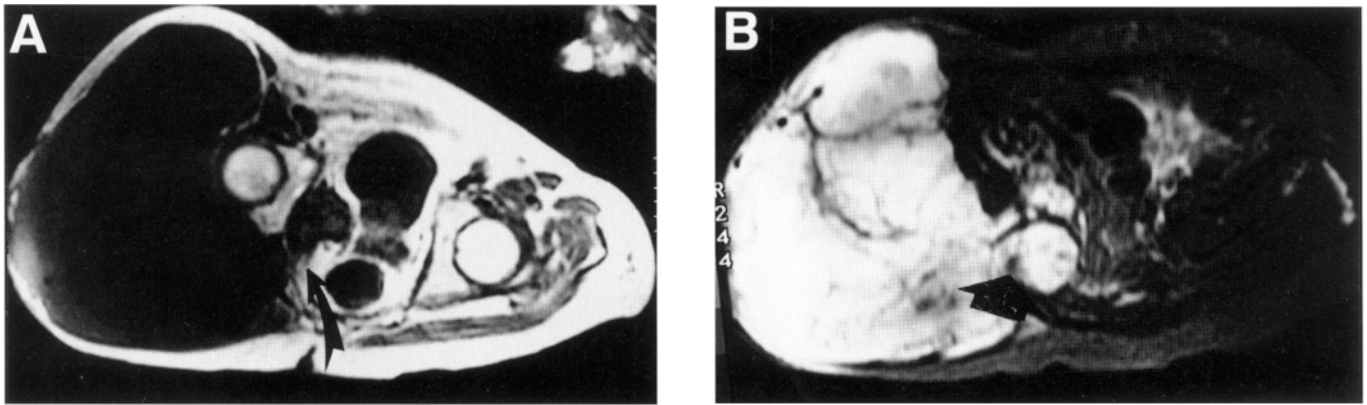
MRI scans of a patient with a large buttock sarcoma considered unresectable that required a hemipelvectomy due to intrapelvic extension of the tumor. (A) T1 weighted image of a MRI scan showing a huge right buttock sarcoma involving the entire gluteus maximus and extending into the anterior thigh compartment. In addition, there is obvious extension into the pelvis through the sciatic notch (arrow). This is the most important area to evaluate for pelvic extension and is the most common route of intrapelvic disease. (B) T2 weighted MRI image of (A) showing obvious involvement of the acetabulum as well as the intrapelvic extension. This patient underwent an extended anterior flap hemipelvectomy due to extension into the pelvis as well as the sacrum (seen on other views).
